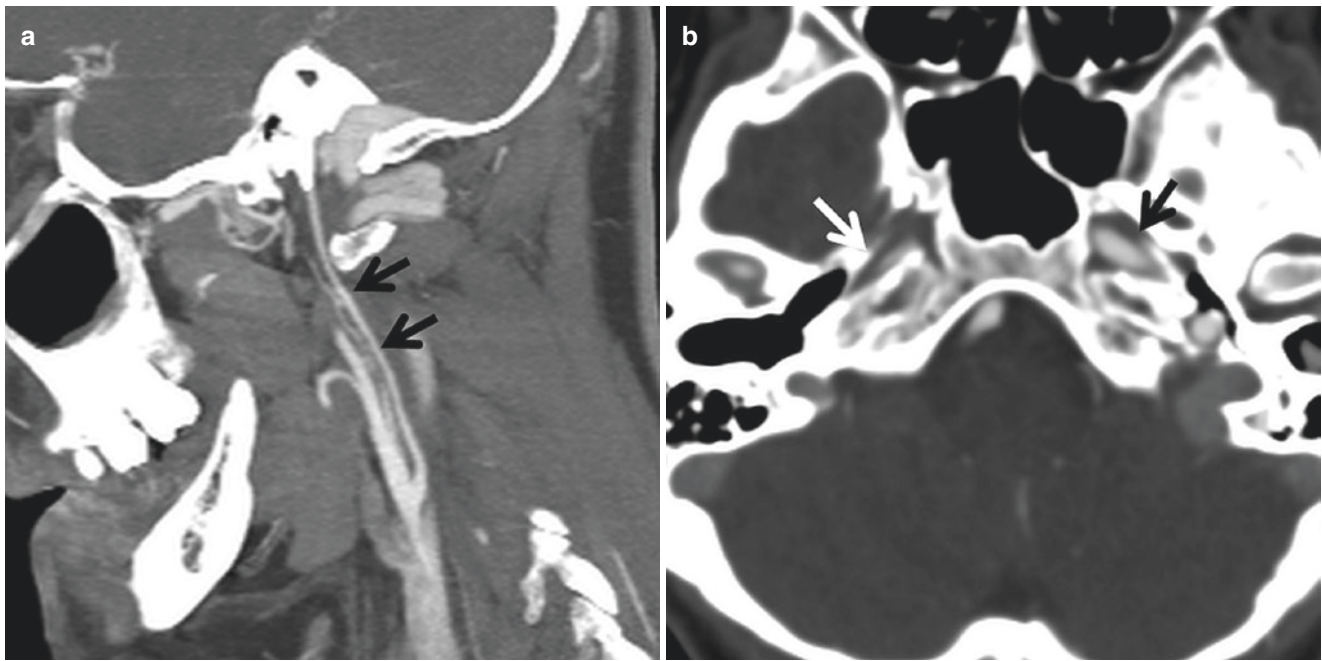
Congenital ICA hypoplasia mimicking injury. (a) Sagittal CTA shows diffuse narrowing of right ICA. (b) Axial CTA shows small right petrous carotid canal (white arrow) compared to the left (black arrow), suggestive of congenital ICA hypoplasia rather than dissection
